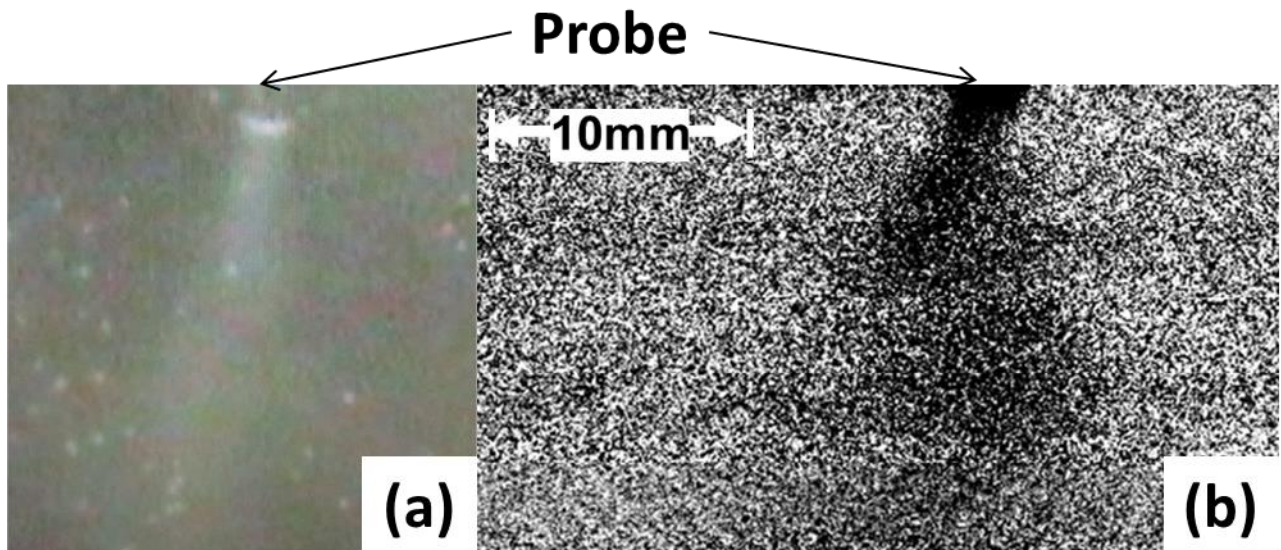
Ultrasound beam (a) Vertical scan of the whole ultrasound beam till 24 mm below the tip of the probe at 20 kHz and 90% acoustic output power (117 W) (b).
